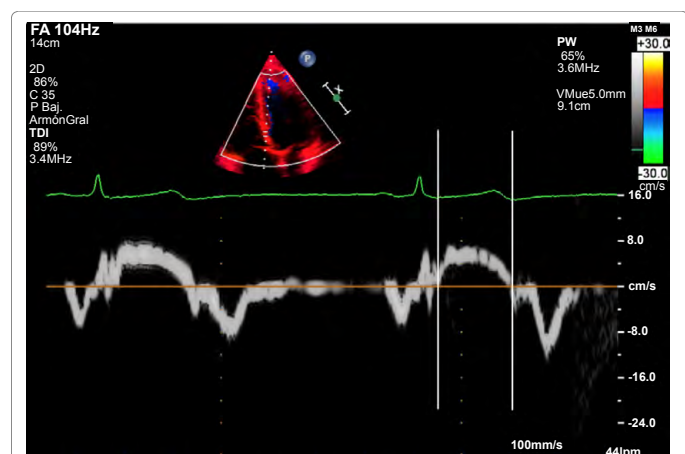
b) Tissue Doppler imaging of the base of the heart which reveals that ventricular motion of the septum coincides with the T wave (between vertical lines).
